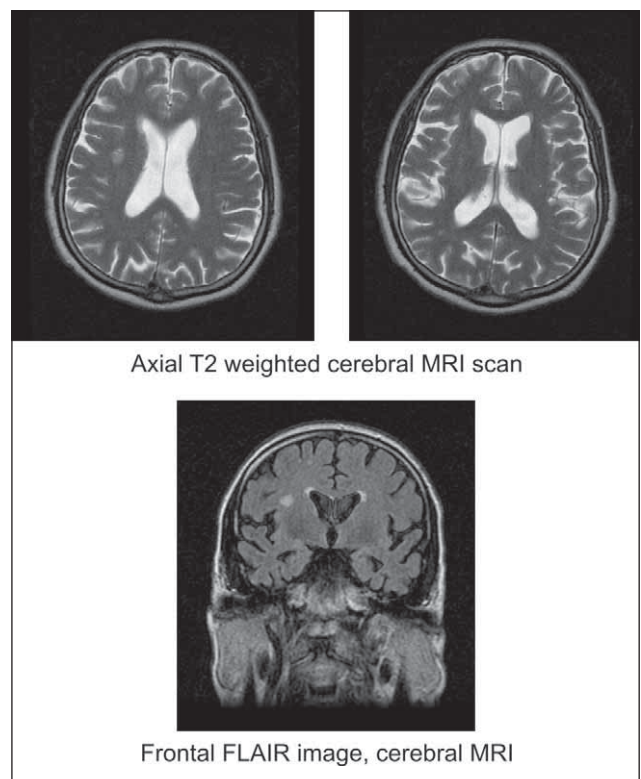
Patient S.B., 60 years, smoker, history of myocardial infarction, admitted for vertigo, memory disturbances and headache. MRI scan shows: leukoaraiosis stage I, deep parietal lacunar infarct on right side.
